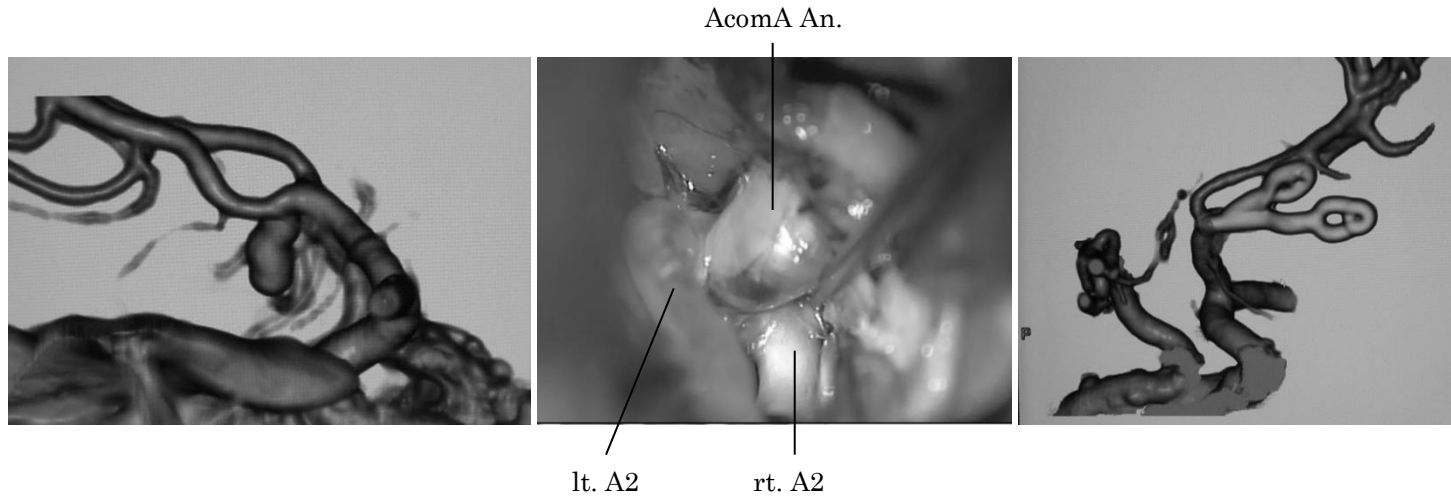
A 53-year-old woman with a large and high positioned AcomA An (A). AIHA was performed. Intraoperative findings revealed an AcomA complex and An.(B). A complete obliteration of the An. and preservation of each branches was confirmed by postoperative CTA (C).
